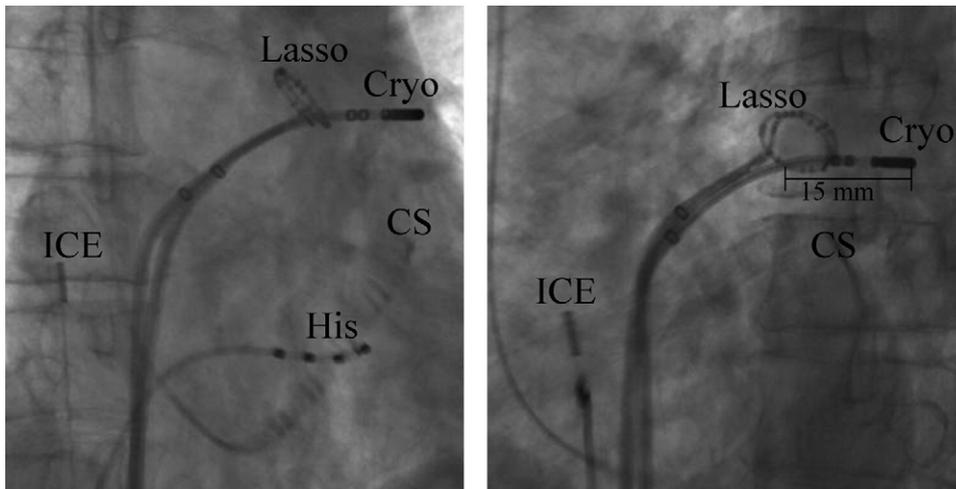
Cryoablation catheter positioned in the PV in the RAO (right) and LAO (left) projections. The Lasso catheter is positioned at the PV ostium. The coronary sinus (CS) and His bundle (His) catheters are in standard position. The ICE catheter is located in the right atrium. Note the cryoablation catheter 15 mm inside the PV ostium as defined by the Lasso catheter. Cryoablation was delivered here to isolate the PV. ICE = intracardiac echocardiography; PV = pulmonary vein.
